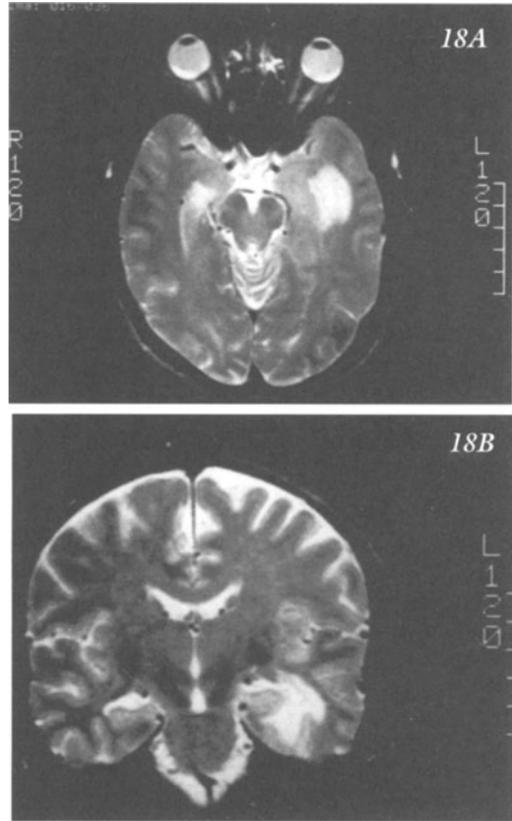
Glioblastoma left temporal lobe. Complex partial seizures with secondary generalization in a 47 year old. Case 22-3. MRI T2 non-enhanced. A) Horizontal section; B) coronal section. (Refer to text.)
